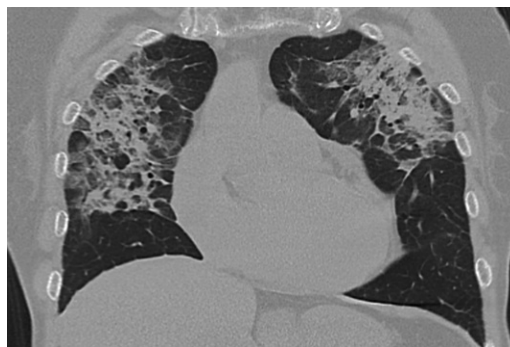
Radiation pneumonitis in a 62-year-old woman with HCC. Coronal CT image of the lungs after TARE shows ill-defined areas of consolidation and ground-glass opacities in a symmetric pattern, with relative hilar or perihilar sparing.
